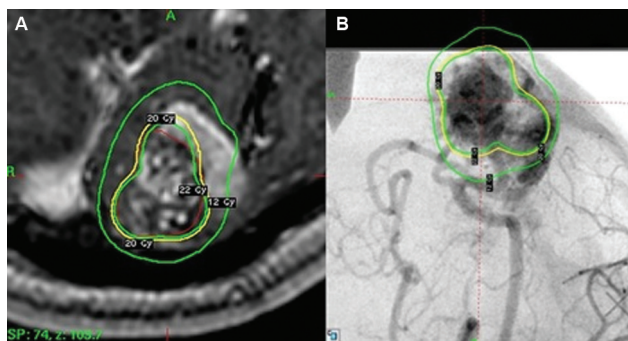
Gamma Knife radiosurgery operative plan. (A) Axial contrasted T1-weighted image and (B) digital subtraction angiography demonstrating the treatment plan to the lesion receiving a marginal dose of 20 Gy (yellow).
